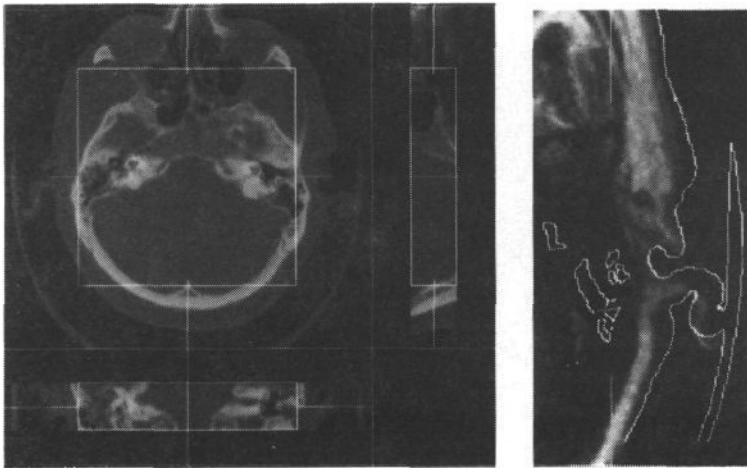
Images showing orthogonal slices through the full CT volume for patient E (left), resulting registration using relative entropy showing deformed CT skin surface threshold on grey level MR (right). White box outline (left) shows truncated CT volume used to limit registration measures to intra-cranial portions of the image.
